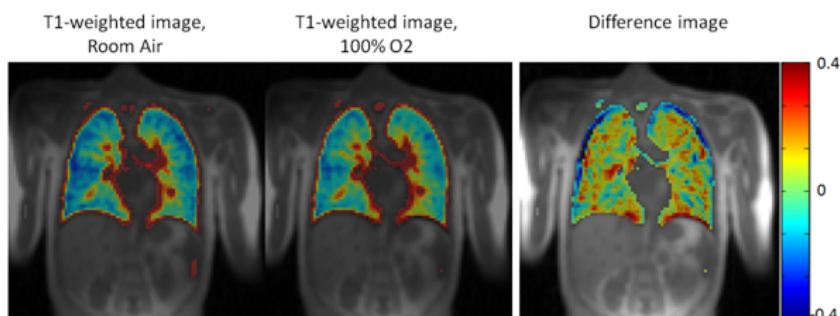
T1-weighted imaging while breathing room air and pure oxygen and the corresponding difference image, which demonstrates the oxygen-transfer into the blood.
